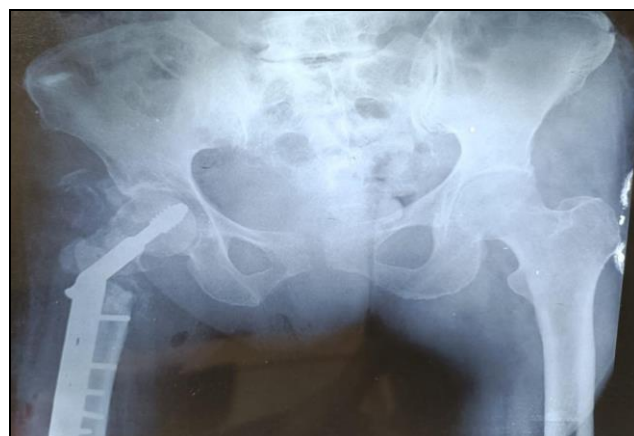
Immediate Post-op x-ray
